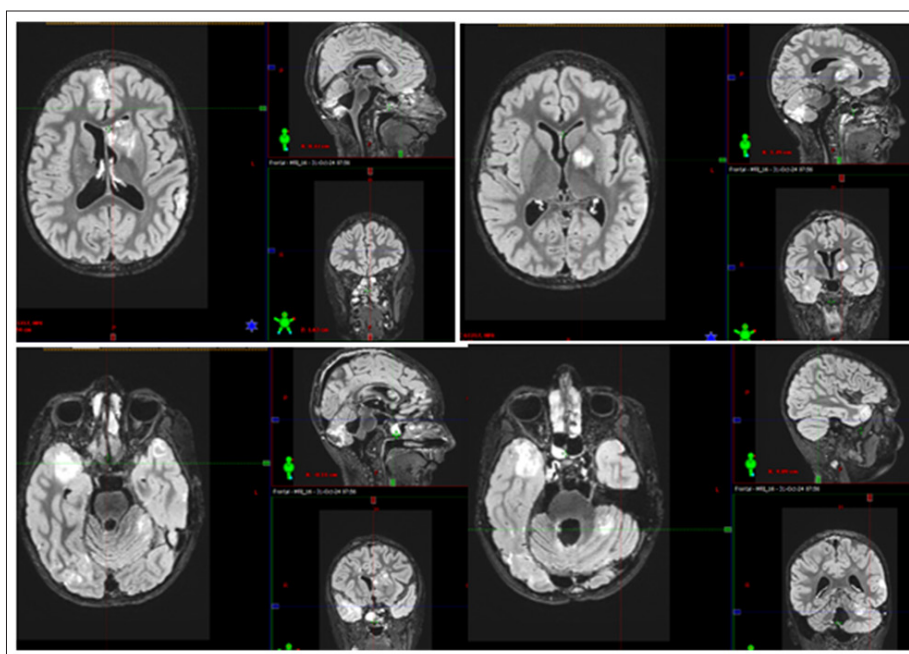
Magnetic Resonance Imaging (MRI) from November 2024 with Rapid Progression in Size of MRI Visible Nodular Lesions in the Caudate Nucleus and Bilaterally in the Retrobulbar Brain Regions.
